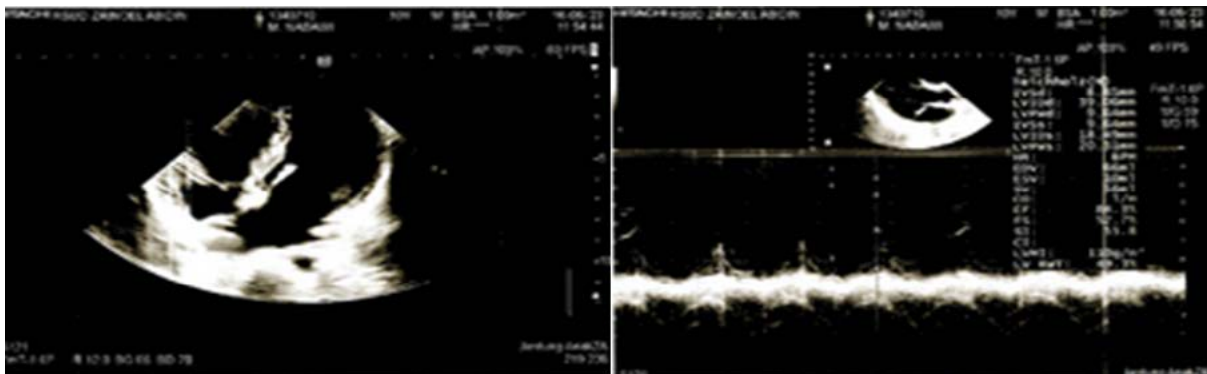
Echocardiography : Mitral Regurgitation
